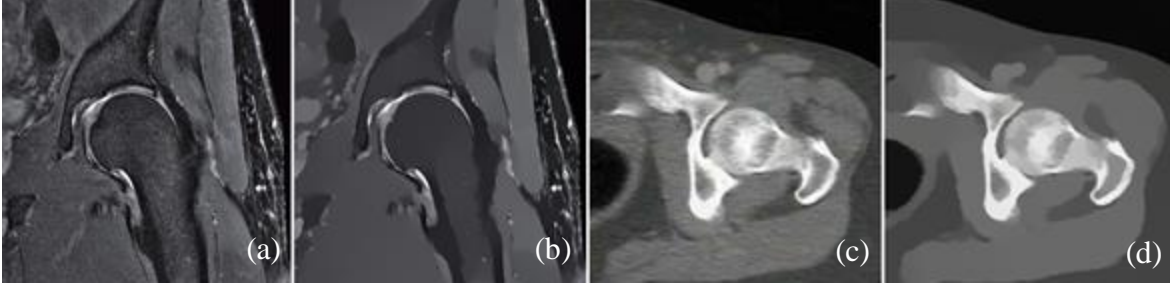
L0-Gradient Minimization (a) original noisy image (b) L0-gradient minimized image with $\rho = 0.01$, $\mu_{rate} = 10$, $\mu = 0.02$, $\mu_{max} = 10^5$. (c) MR image of knee joint (d) L0-gradient minimized image with $\rho = 0.015$, $\mu_{rate} = 20$, $\mu = 0.03$, $\mu_{max} = 10^5$.
